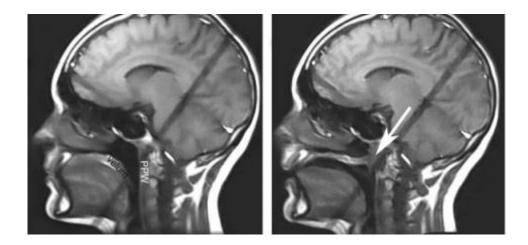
Midsagittal magnetic resonance imaging of velopharyngeal mechanism at rest (A) and during speech production (B). The white arrow is pointing at the velar eminence during elevation. (PPW - Posterior Pharyngeal Wall)
